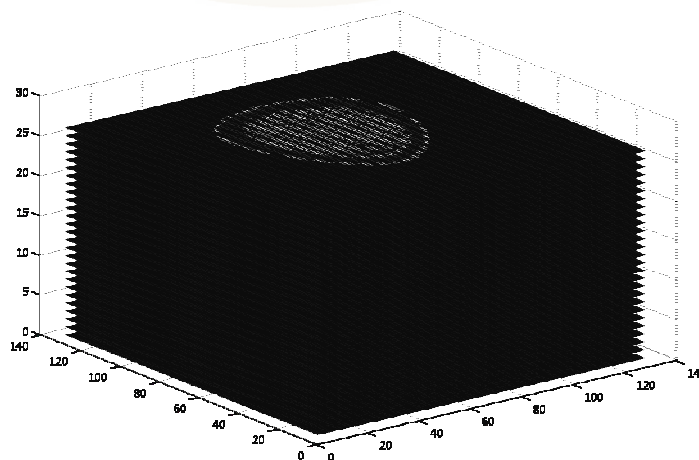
Aligned CT series
